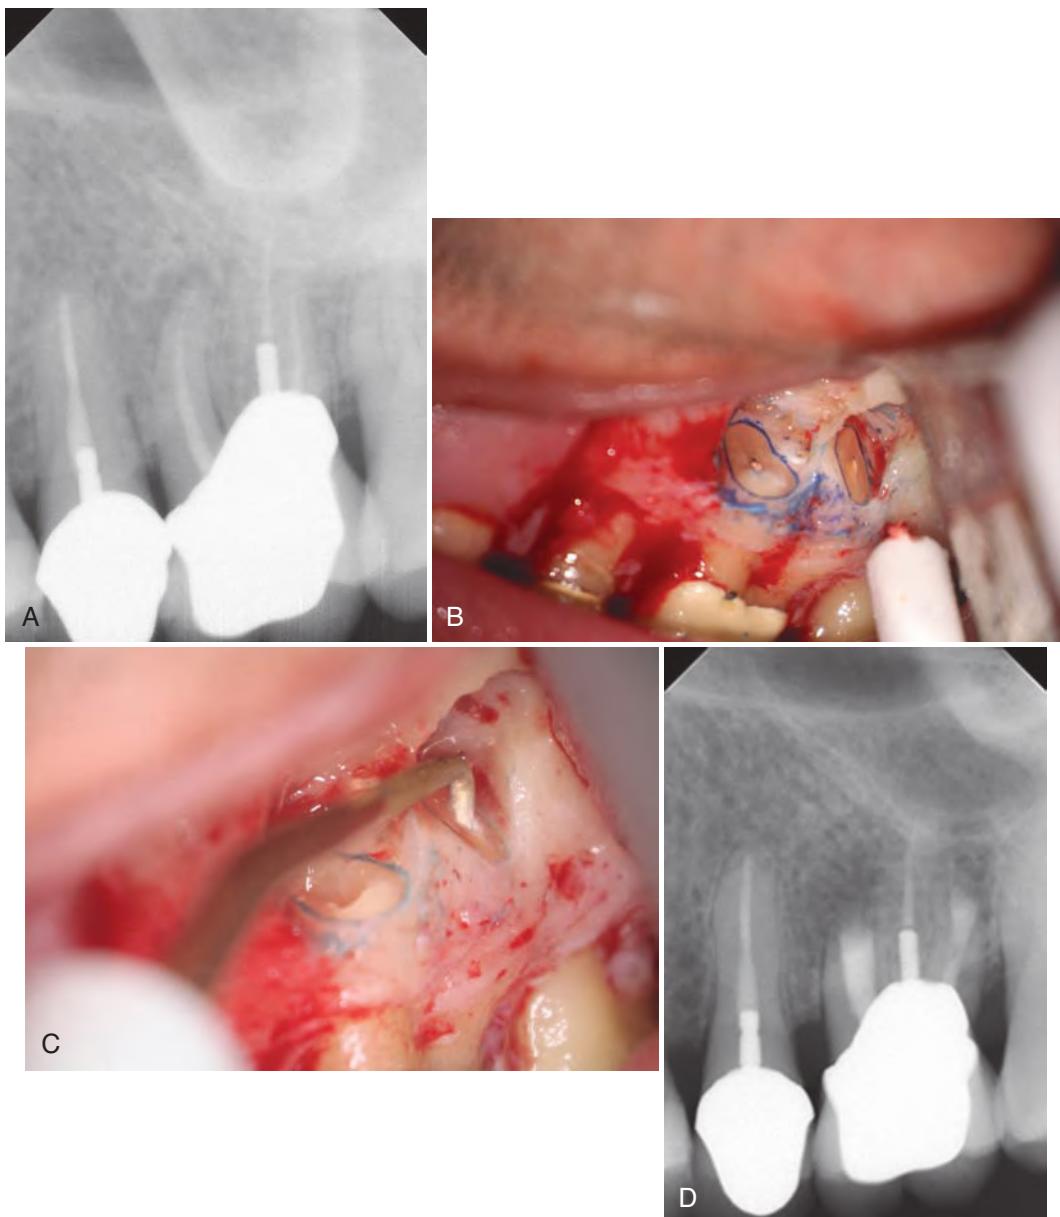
Apical surgery. A, Preoperative radiograph. B, root apex exposed; and C, root apex resected and restored. D, 3-month postoperative radiograph. (Courtesy Dr. Peter Tawil.)
